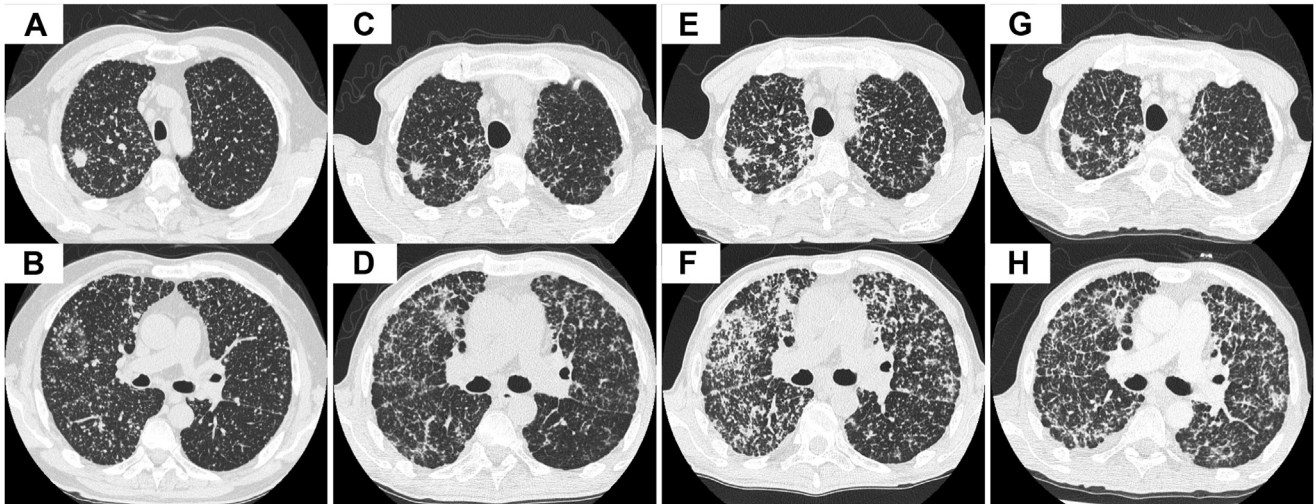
Chest computed tomography images (A, B) at first visit, (C, D) after 4 cycles of first-line treatment, (E, F) after two cycles of maintenance therapy, and (G, H) 1 month after sotorasib initiation.
